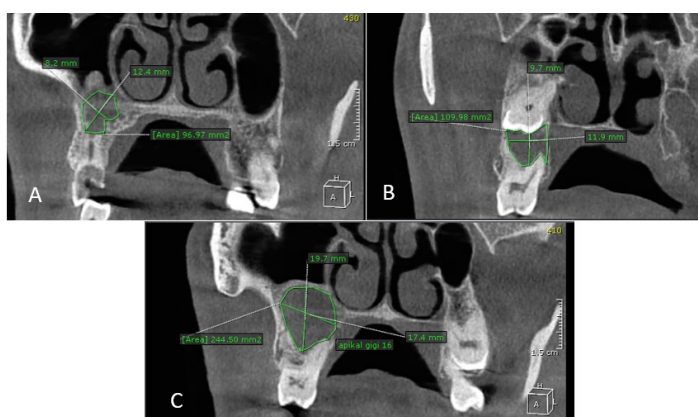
CBCT coronal view showing the right maxillary third molar has a radiolucent image, well defined border, surrounding the crown of the right maxillary third molar to the apical of the (A) right maxillary second premolar, (B) first molar and (C) second molar
